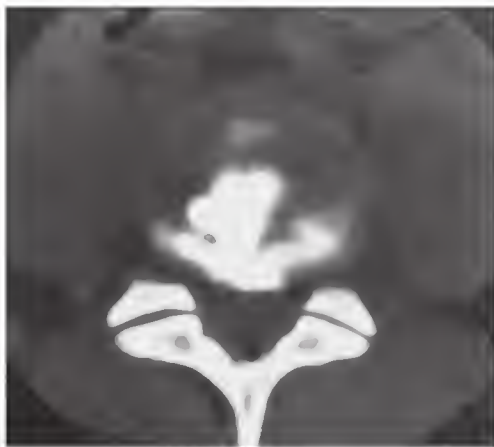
Postdiskography computed tomography demonstrates painful grade 4 disruption of an annulus fibrosus.
